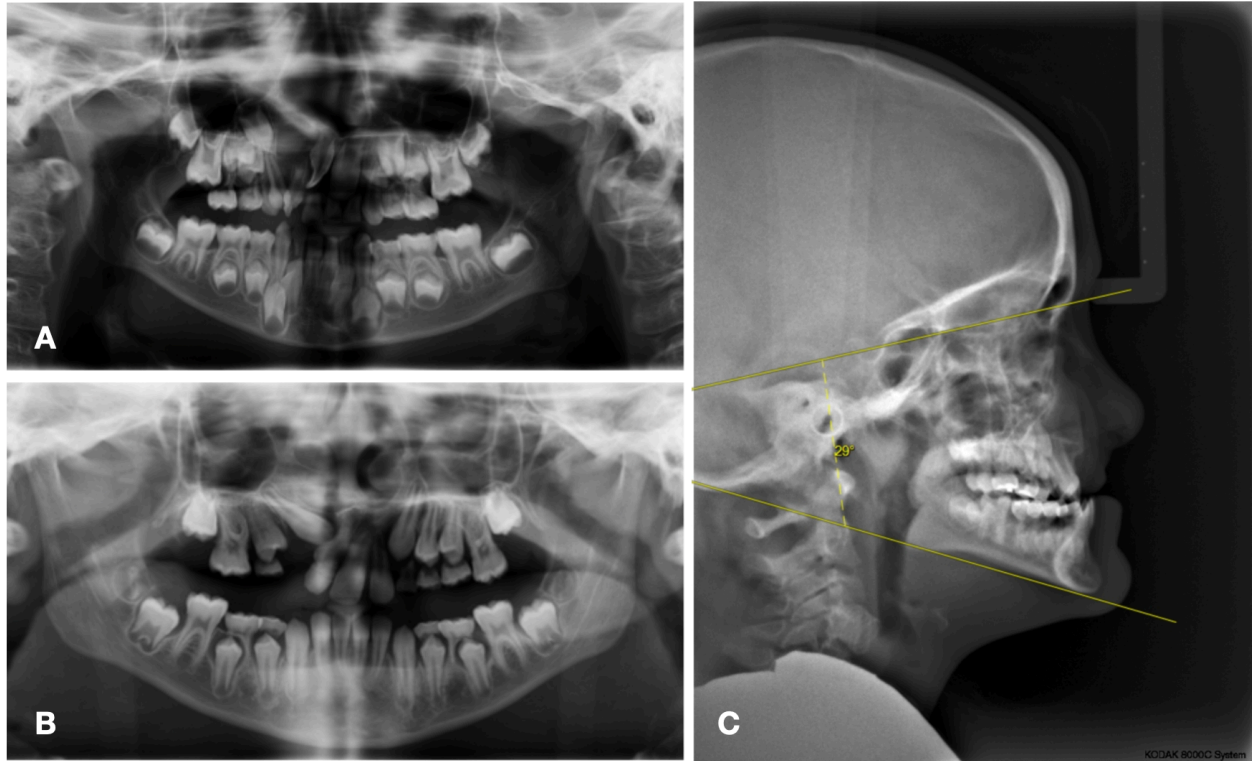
shows ectopic eruption of maxillary 1st molars in a subject. Figure 2B depicts a radiographic example of infraocclusion of primary molars. Figure 2C demonstrates cephalometric measurement of mandibular plane angle (SN-MP).
